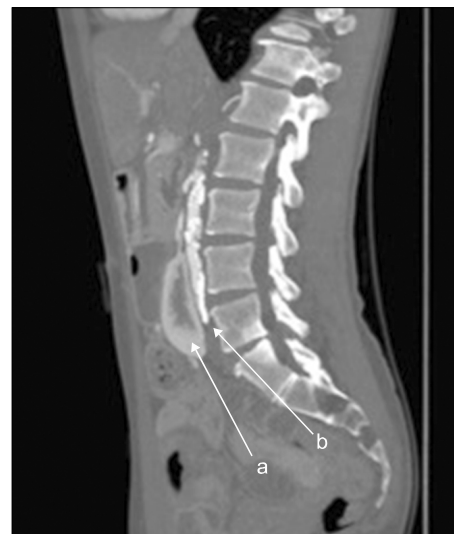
Coronal computed tomography depicting (a) crossing renal ectopic tissue and (b) severe occlusive aortic bifurcation disease.
